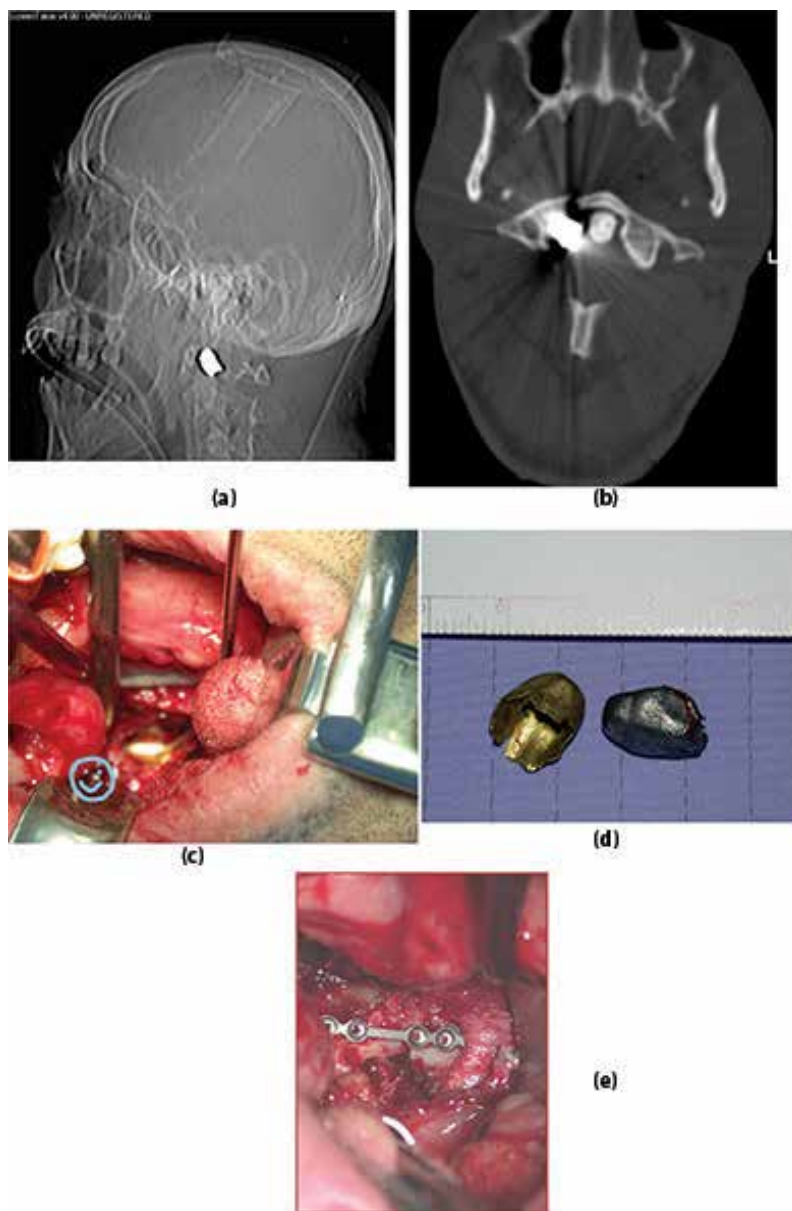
A 30-year-old patient, who sustained a low-velocity gunshot wound. He had a few entry wounds in his head and neck. He was conscious, alert, and hemodynamically stable with normal neurological status. The following images describe the evolution of events. (a) Plain radiograph showing the patient's skull with a bullet located at the center; (b) axial CT scan showing the broken arc of C1 with the bullet located next to the dens; (c) trans-oral approach to C1 vertebra with the bullet at the base of the surgical dissection. The smiley gives the orientation of the patient's face; (d) the bullet is shown outside of the patient's spine; (e) C1 ring following osteosynthesis.
